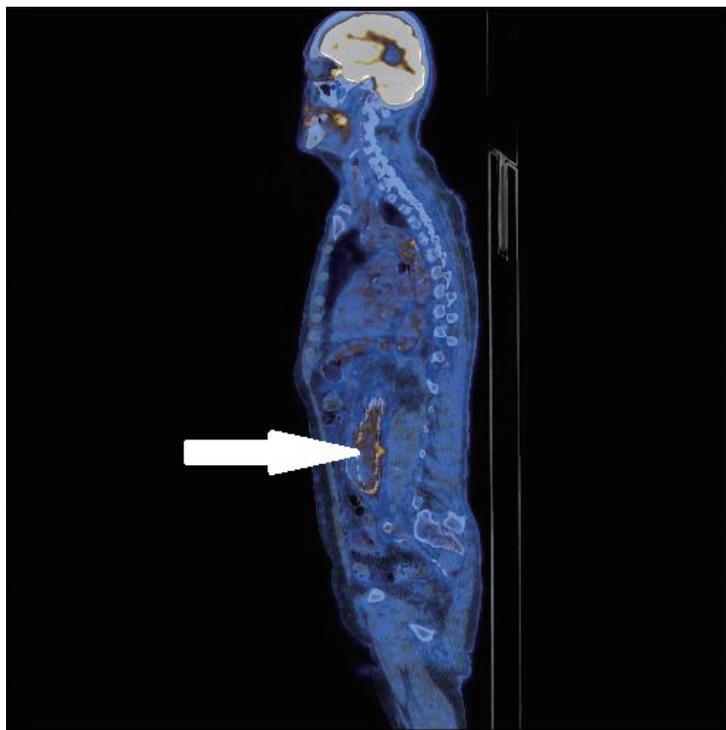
Image of PET-CT in the sagittal plane on the same patient after surgery. Arrow, marked focus moderately increased metabolism ^{18}F -FDG in the retroperitoneal space – residual reactive changes. (Changes with a history catheter sepsis). No outbreaks of increased metabolic fluorodeoxyglucose. No evidence of cancer of increased FDG metabolism.
